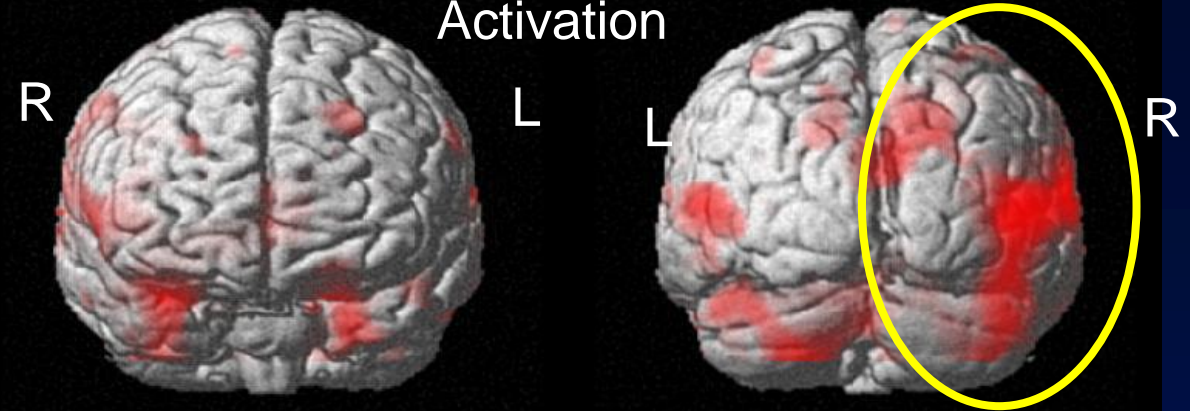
and 4 from Arnow BA, Millheiser L, Garrett A, Lake Polan M, Glover GH, Hill KR, Lightbody A, Watson C, Banner L, Smart T, Buchanan T, Desmond JE. Women with hypoactive sexual desire disorder compared to normal females: a functional magnetic resonance imaging study. *Neuroscience*. 2009;158:484-502.
